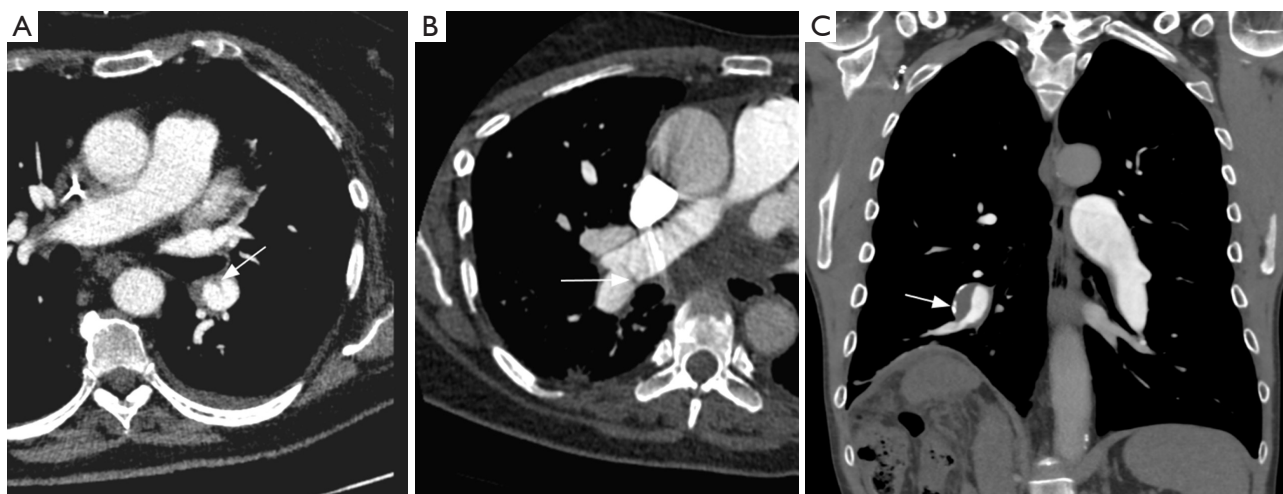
CT pulmonary angiography appearances of chronic thrombi in different patients. Axial images (A) and (B) show webs (arrows), reflecting non-resolved thrombi and partial recanalization. Coronal image (C) shows an eccentric thrombus in right interlobar pulmonary artery with calcified mural thickening (arrow).
